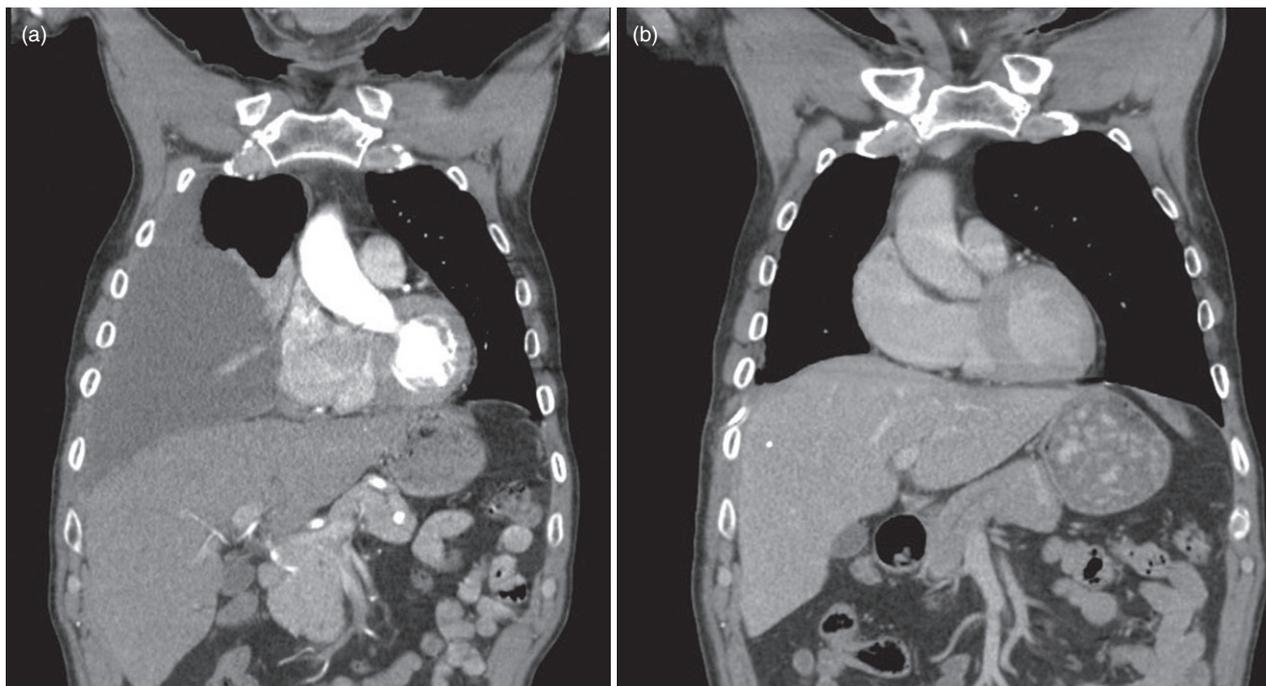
(a) Computed tomography (CT) scan (coronal view) shows a large right pleural effusion that required indwelling pleural catheter (IPC) drainage for malignant pleural effusion management. (b) CT scan performed a few weeks later shows complete resolution of the effusion following spontaneous pleurodesis. The IPC was removed with no recurrence of effusion on follow-up.
